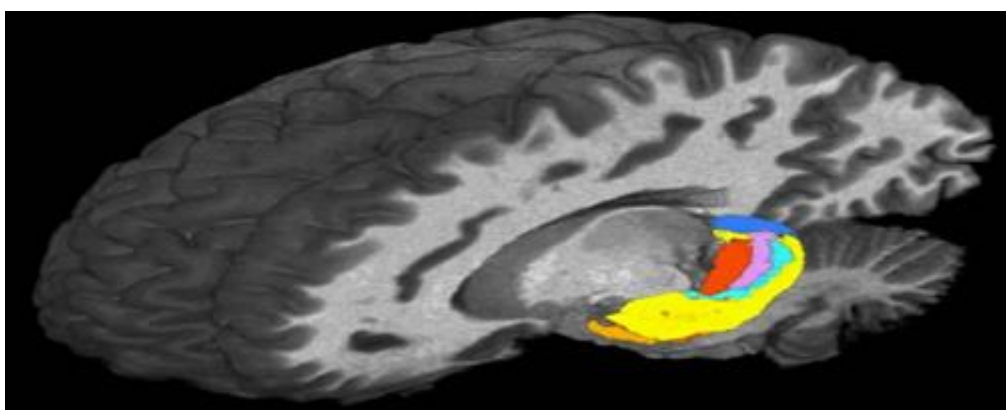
Ultra High Field MRI Detects Differences in Brain's Hippocampus (8).
